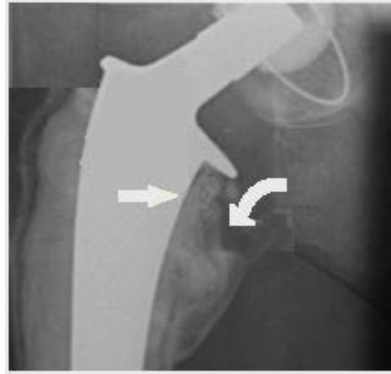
Radiographic image showing the loosening [17]
